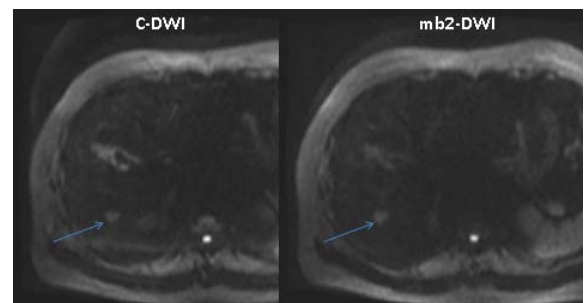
Right hepatic lobe hepatocellular carcinoma (arrow) was visualized on c-DWI and mb2-DWI by all readers
